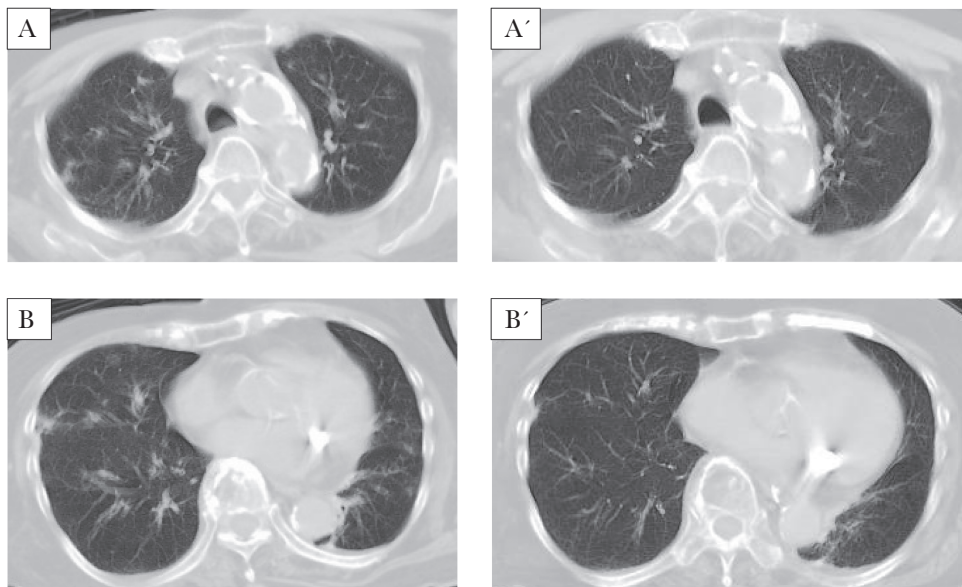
Computed tomography (CT) improvement through human metapneumovirus outbreak. Bronchial wall thickenings in the proximal bronchus and multiple lobular opacities seen during the outbreak (A and B) were diminished after the remission of the symptoms (A', B'). Chest CTs from a 77-year-old female are shown.
